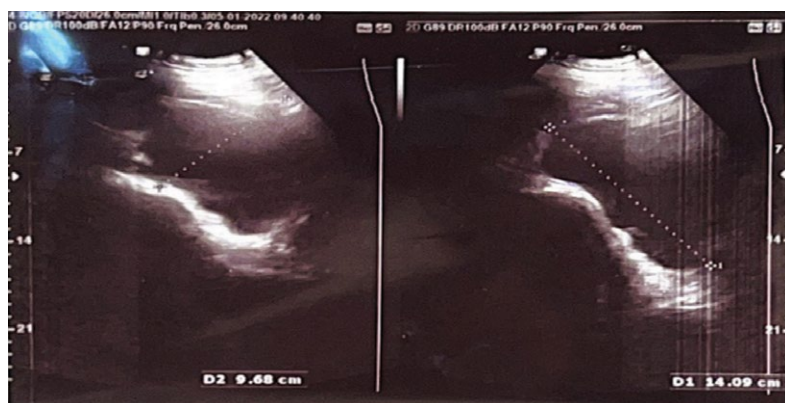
Ultrasound image of the left ovarian cyst before Caesarean section
